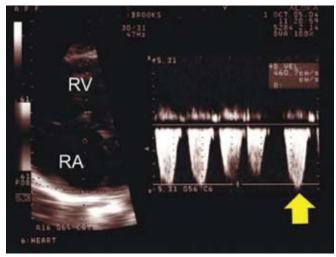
The left side of the image reveals the anatomic site (tricuspid valve) where the Doppler echocardiogram was obtained. Note the elevated tricuspid regurgitation velocity (4.7 m/s), which is consistent with systolic pulmonary arterial hypertension (arrow). RA, right atrium; RV, right ventricle.
